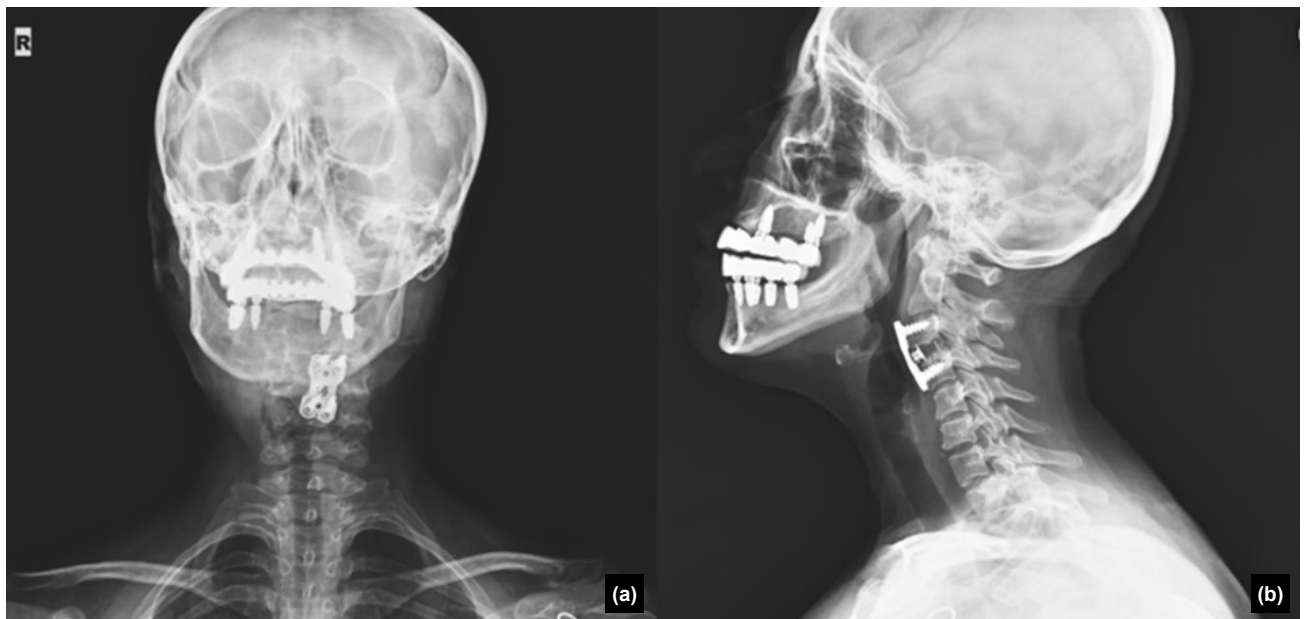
(a) Coronal and (b) sagittal cervical spine X-rays demonstrating displaced C3 fractures with postoperative instrumentation.
